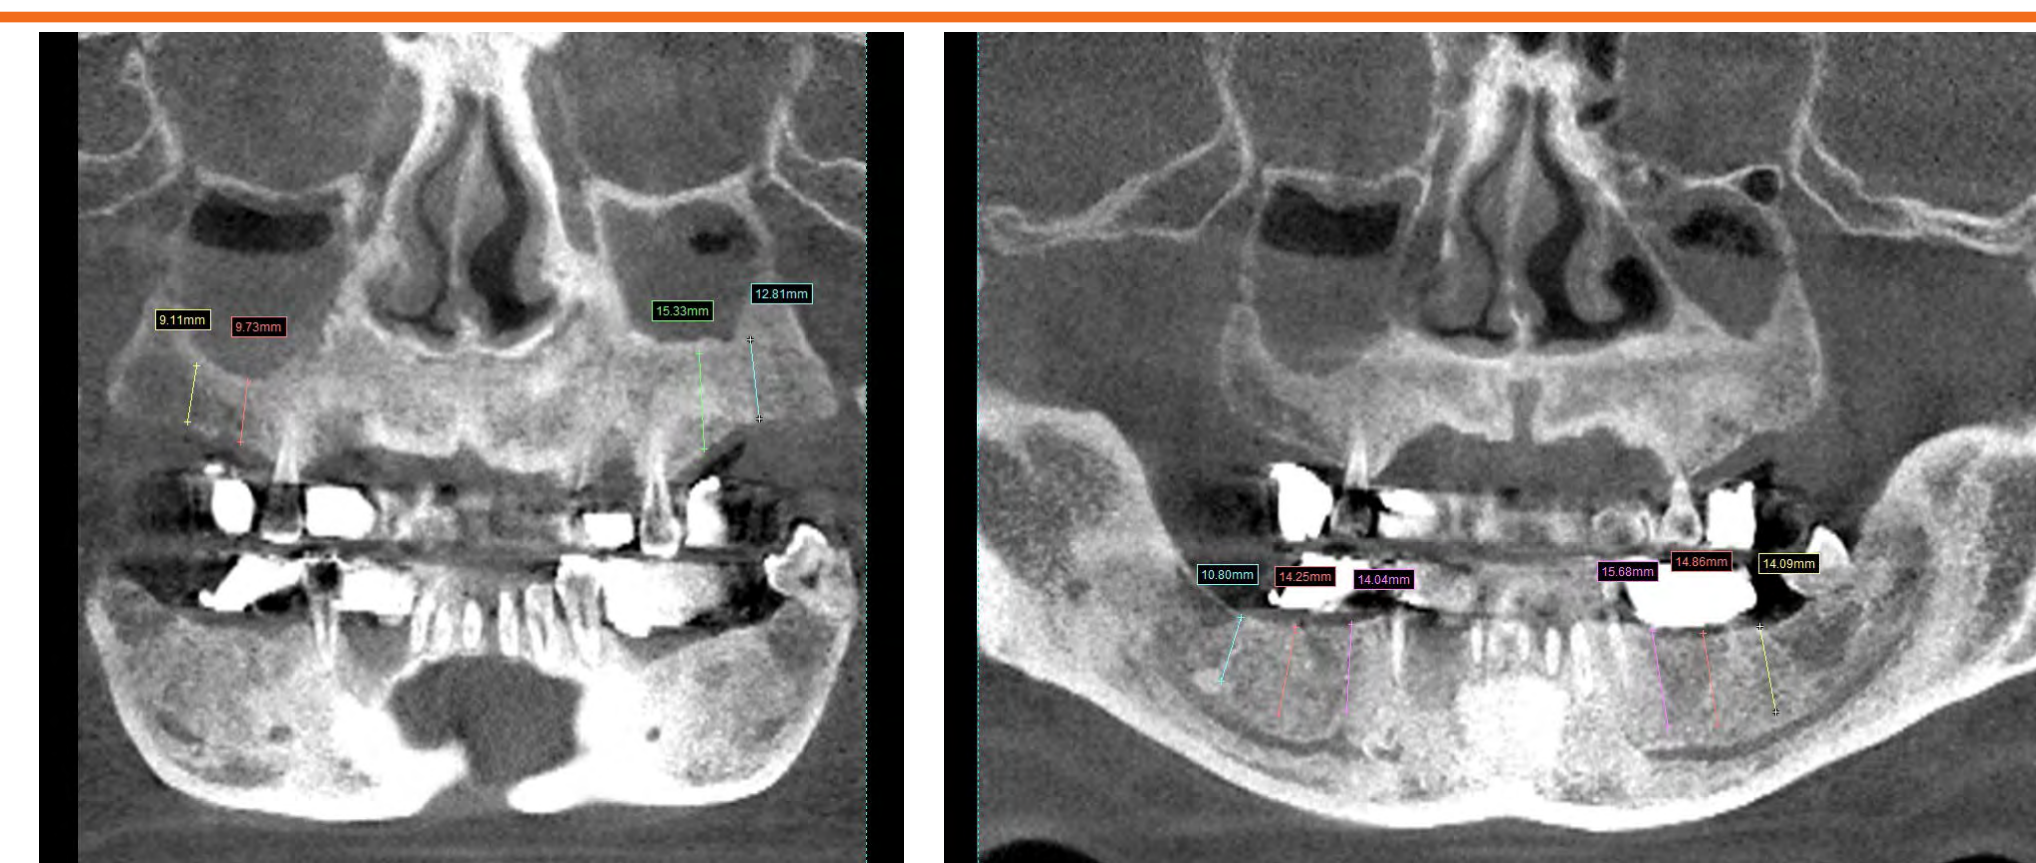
A CBCT reformatted panoramic radiograph
